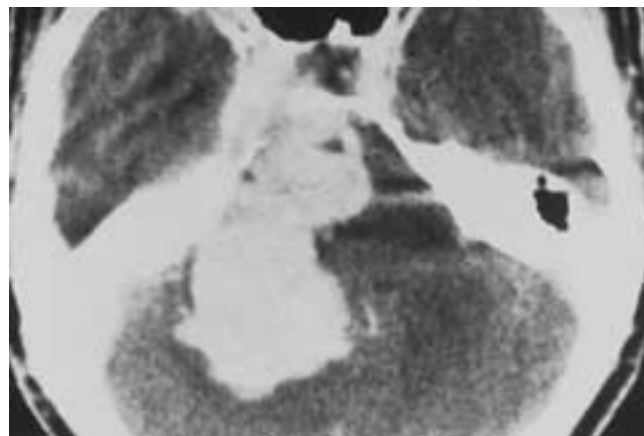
Large glomus jugulare tumor. Postcontrast CT. Fisch type D tumor with large intracranial tumor and cavernous sinus extension, usually considered incapable of resection.
